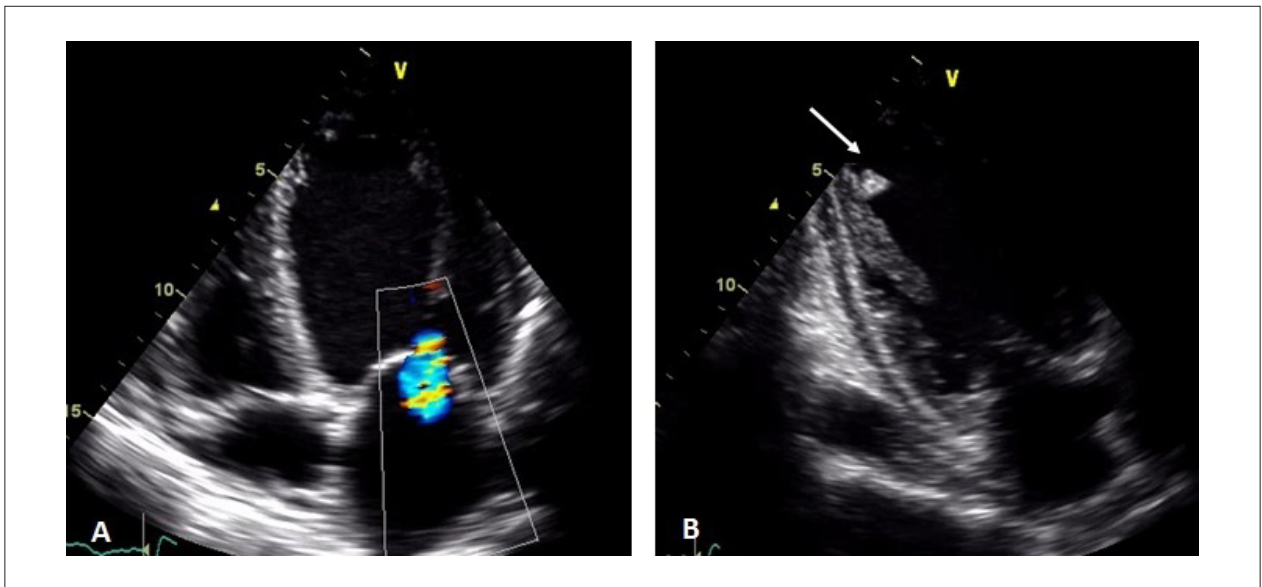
Transthoracic echocardiogram at admission showing the presence of dilated cardiomyopathy, with mitral regurgitation due to poor coaptation of the valve leaflets (A) and thrombus adhering to the apex (arrow) (B).
